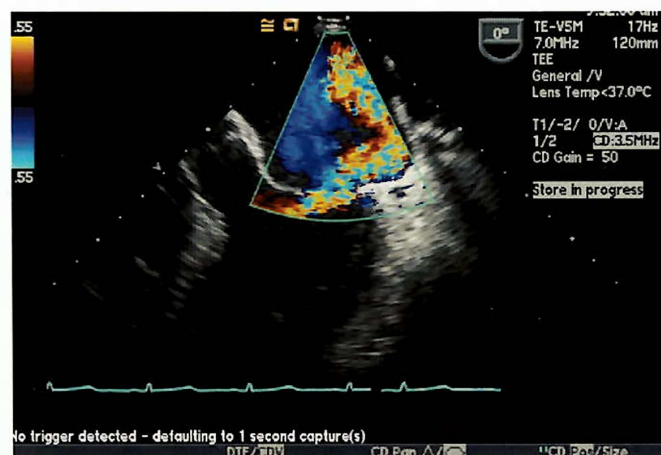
Midesophageal five-chamber view in systole with color flow Doppler demonstrating significant mitral regurgitation
